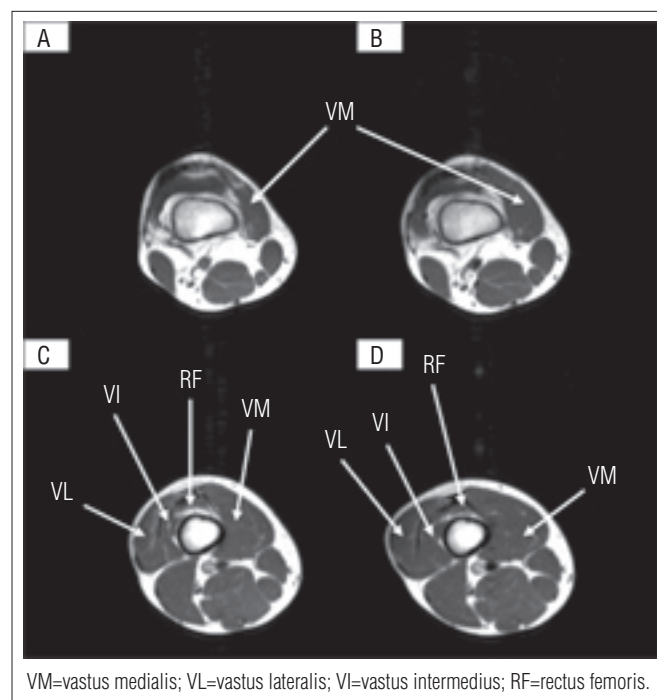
Representative axial T2-weighted MRI of the involved limb, before (A and C) and after training (B and D) of the same subject. The images were obtained between 6 cm (A and B) and 20 cm (C and D) from the proximal border of the patella.
